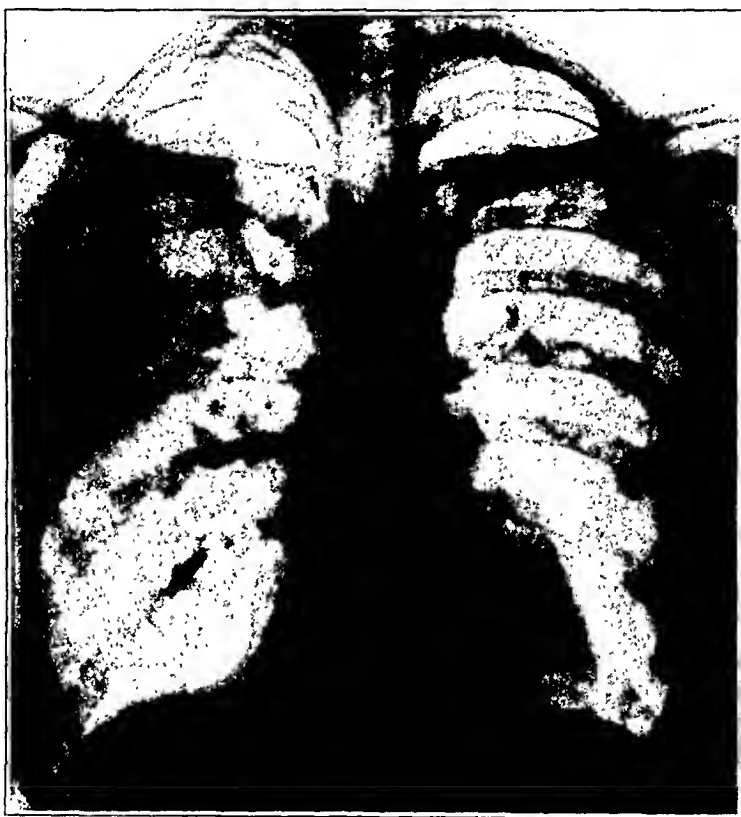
(case 8).—Roentgenogram, showing area of pneumonia (March 19, 1929). No cavity is visible. No subsequent plates were taken. The area of necrosis was discovered at autopsy.
